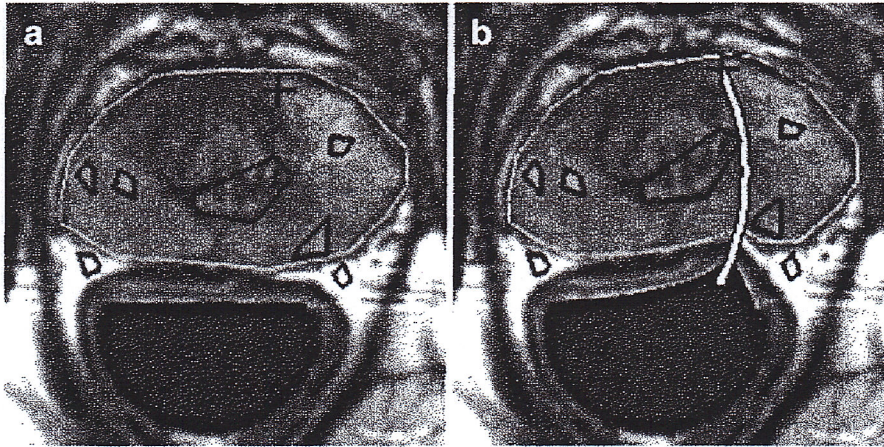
A needle steering planner that considers 2D tissue deformation [6] (© 2005 IEEE), reprinted with permission. The magnetic resonance images show a tumor target (*cross*) in the prostate with obstacles that preclude a straight-line trajectory. The images show (a) the initial configuration and (b) a planned path for a bevel-tip steerable needle deployed from a transrectal probe. This locally optimal plan compensates for tissue deformations, avoids obstacles, and minimizes insertion distance
